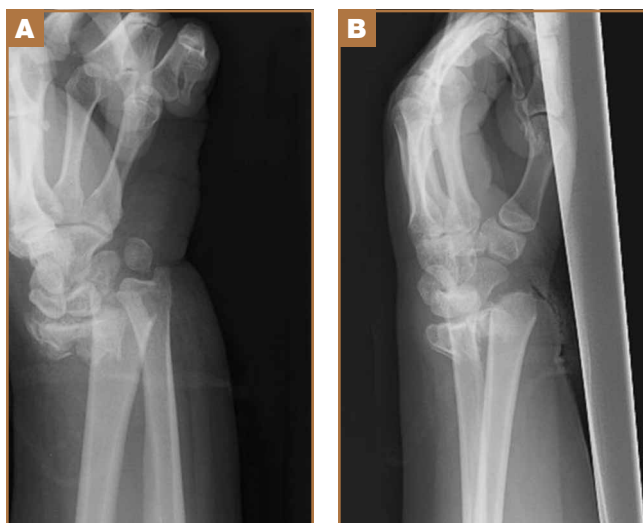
Postreduction (A) anteroposterior and (B) lateral radiographs of right wrist.
